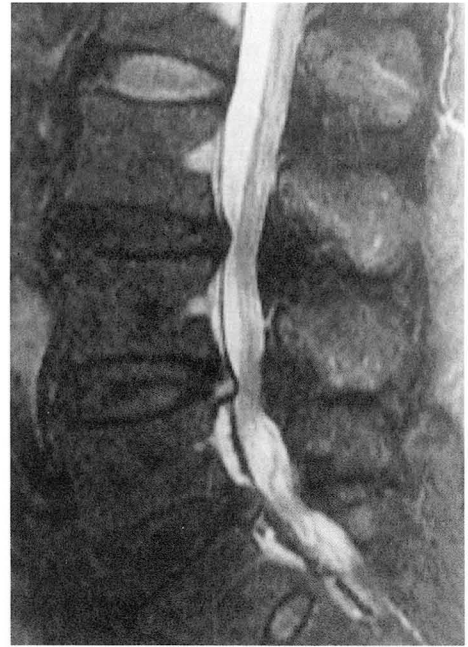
T2-weighted sagittal image. Moderate redundancy of nerve roots is defined caudal to the moderate constriction of spinal canal at L4-5.
